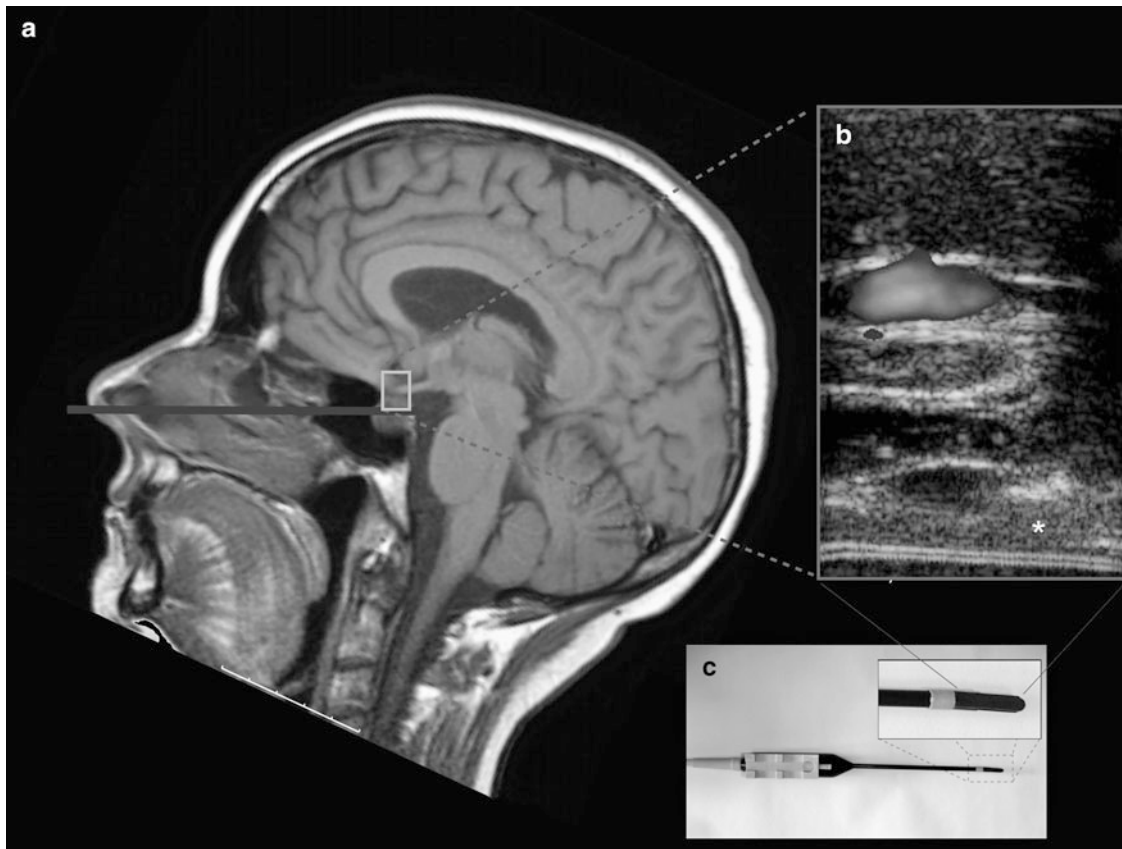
The use of ultrasound in pituitary surgery, with the probe and dimensions of the image overlaid on a MR image (a) and the intraoperative US image showing residual tumour (indicated with *) (b), and the US probe with the side firing transducer array (c). In the middle of figure b is the optic chiasm, and above is the communication artery
